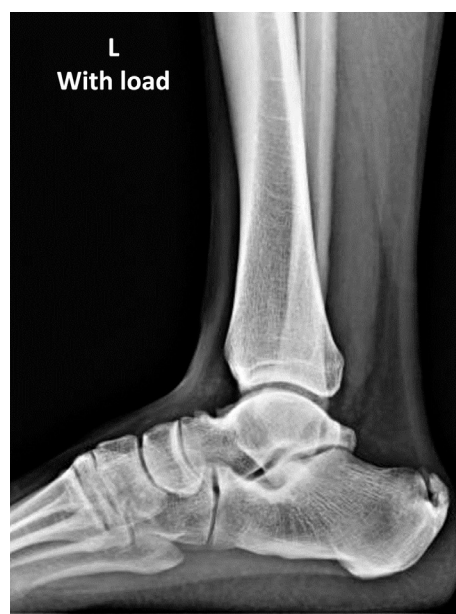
Lateral radiograph view showing insertional enthesophyte and tendinosis.
